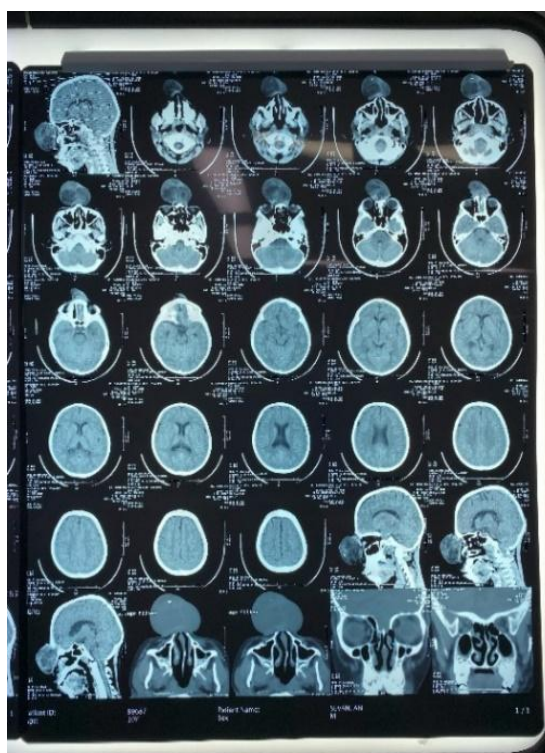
CT-Scan image show herniation brain tissue, meninges, and CSF protruding through the defect in the frontal bone of the cranium.
